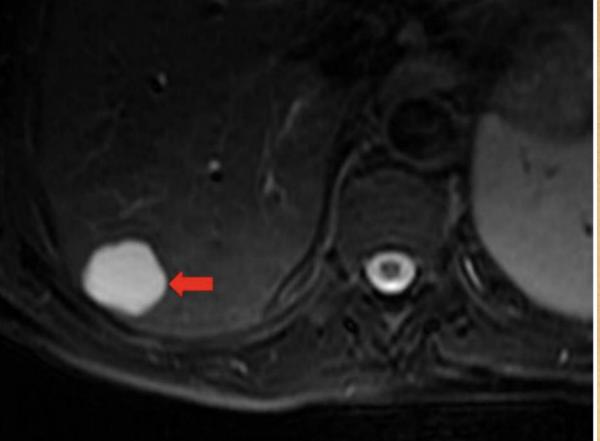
Axial T2-weighted MR image showing a simple hepatic cyst (arrow).
